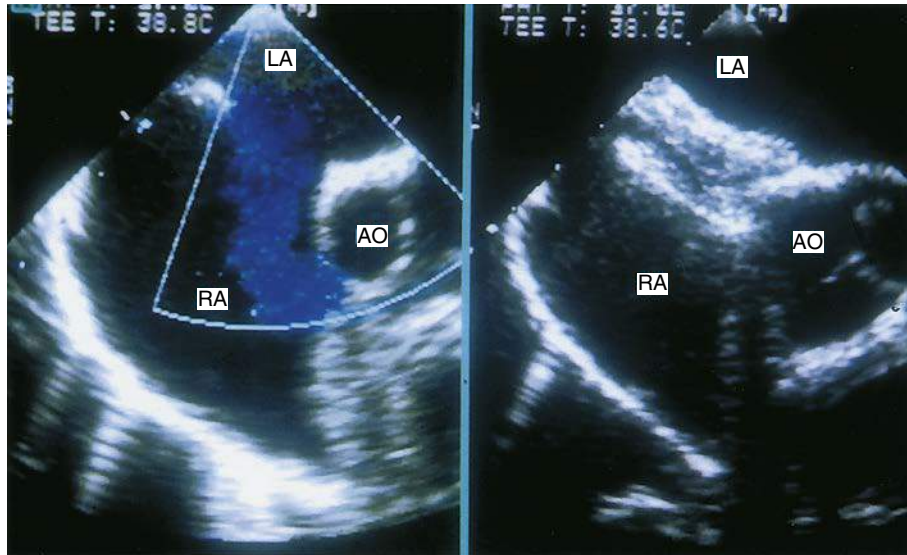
Transesophageal echocardiogram from a patient in whom an Amplatzer occluder was used to close an anterior oval fossa defect. AO, Aorta; LA, left atrium; RA, right atrium.
